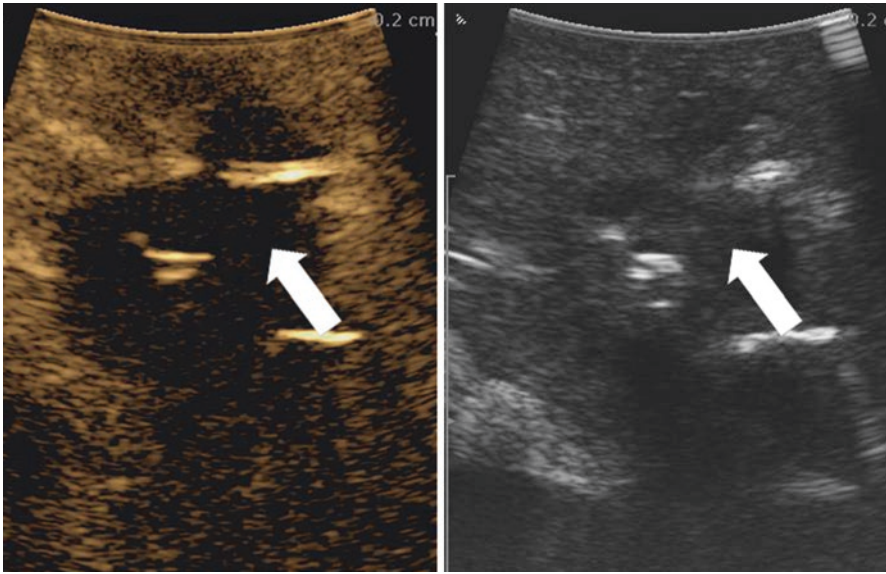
The hypoechoic area in conventional ultrasound appeared as non-contrast enhanced area in contrast enhanced ultrasound (*arrow*)
